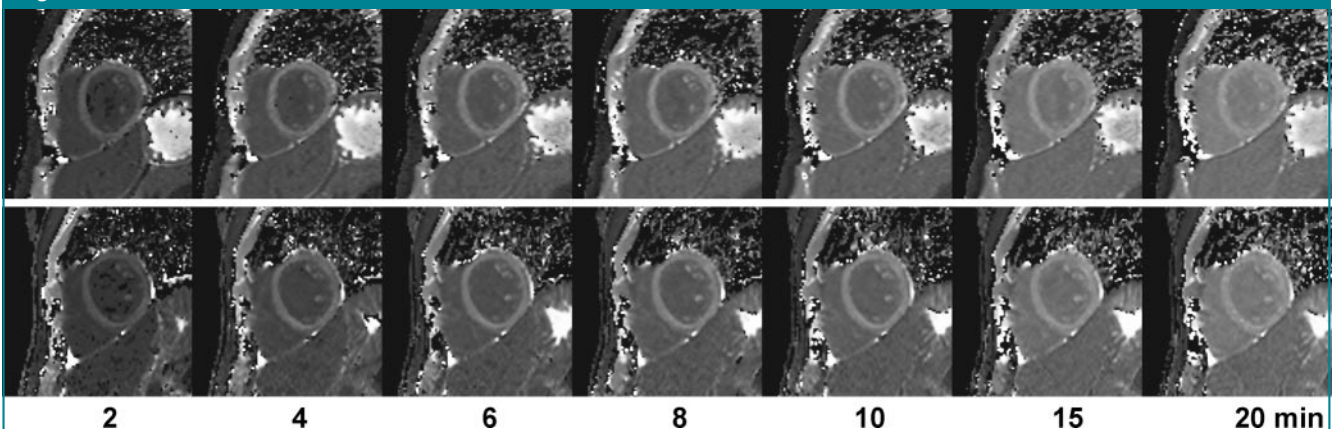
Representative postcontrast midcavity short-axis MOLLI T1 maps from study 2 (top) and 3 (bottom) in volunteer 5. Image quality is consistent for the full range of T1 values during washout of the contrast agent. Each of these maps was based on 11 steady-state free precession source MR images (3.90/1.95; flip angle, 50° ; matrix, 240×151 ; section thickness, 8 mm).
